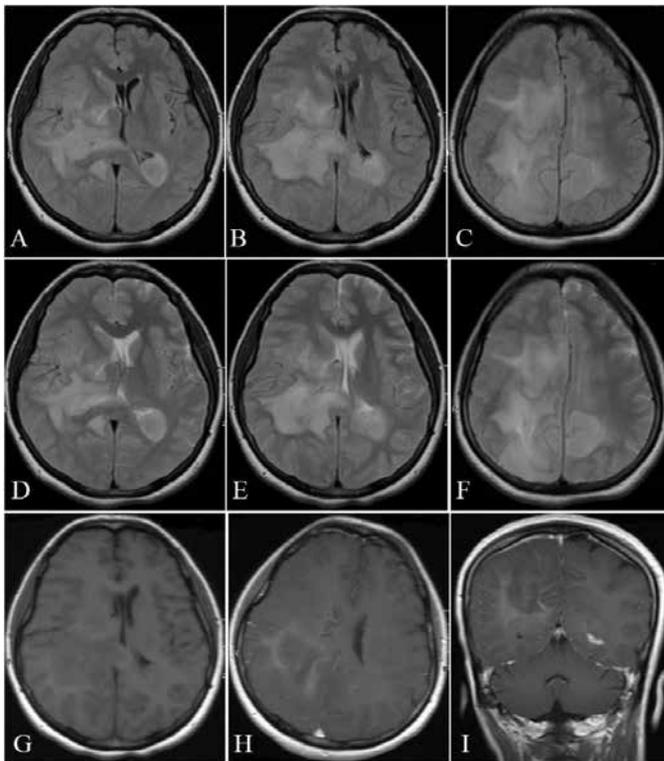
MRI showing vaguely outlined infiltrative lesions in her bilateral frontal and parietal lobes, splenium of the corpus callosum, right temporal lobe, right thalamus and basal ganglia, appearing hypointense in the axial FLAIR (A, B, C) and T2-weighted (D, E, F) slices and iso-hypointense in the T1-weighted (G) slice. Secondary to the mass effect, right ventricle is compressed and there's a shift towards left. There is mild contrast in the lesion areas on the parietal lobes seen in the post-contrast T1-weighted axial (H) and coronal (I) images.
